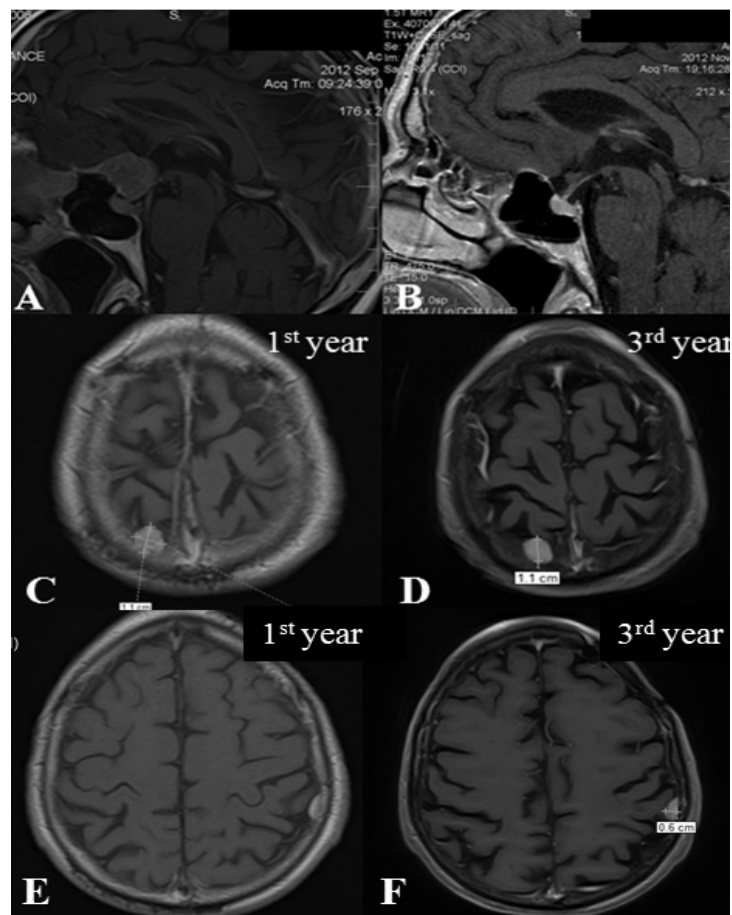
(Case 1) Preoperative (A) and postoperative (B) sagittal T1-weighted images with contrast. Multiple meningiomas with one right parietal meningioma (C) and one left parietal meningioma (E)
